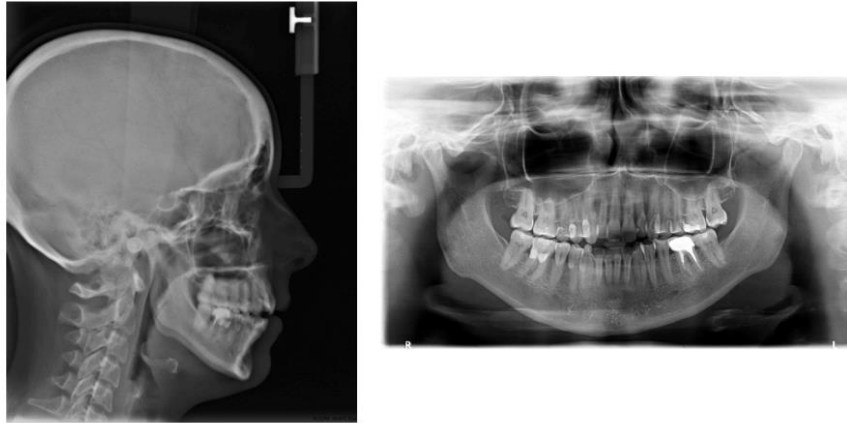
Pre-treatment teleradiography and panoramic radiography
